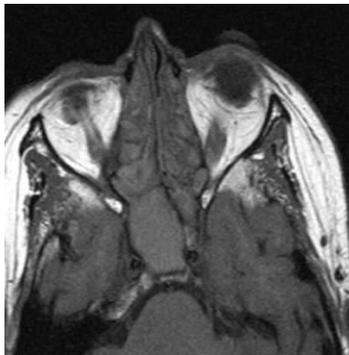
CT and MRI .Hyperdense on CT (a)Allergic fungal sinusitis moderately high T1WI (b), low on T2WI with expanded sinus.
